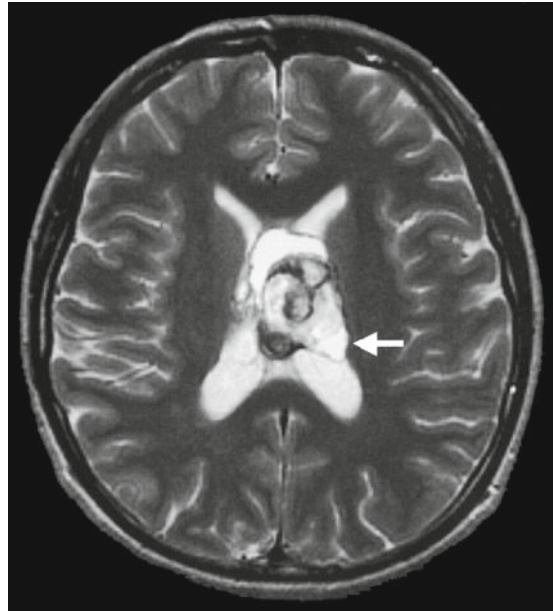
A 28-year-old woman with a papillary glioneuronal tumor involving the corpus callosum and lateral ventricles. A mass with mild peritumoral edema shows variable signal intensities on T2-weighted image because of intratumoral hemorrhage and calcification. The left dorsal portion (*arrow*) showing very high intensity on T2-weighted image was subacute hematoma. Rim-like low intensity reflects hemosiderin deposition
